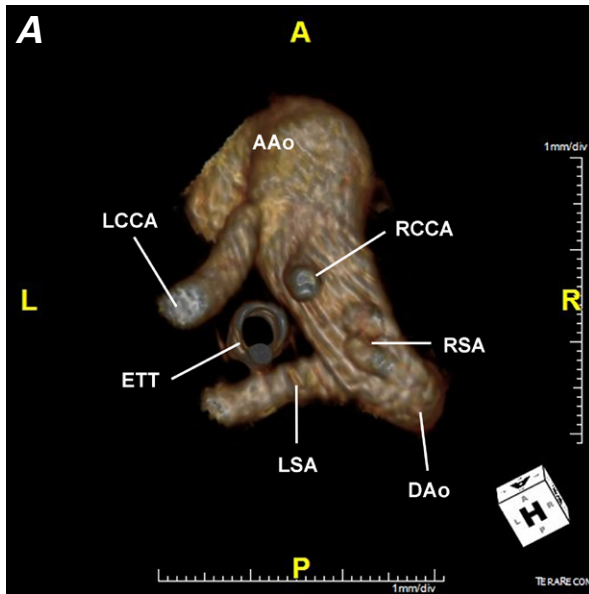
Patient 1. Computed tomogram (volume-rendered 3-dimensional reconstruction). A) View from the head shows the origin of the brachiocephalic vessels and an incomplete vascular ring. B) Posterolateral view of the origin of the left subclavian artery shows a nondilated proximal portion, excluding the Kommerell diverticulum. Absence of a left-sided ductus arteriosus precludes a vascular ring. Endotracheal tube (center) marks the tracheal position.
